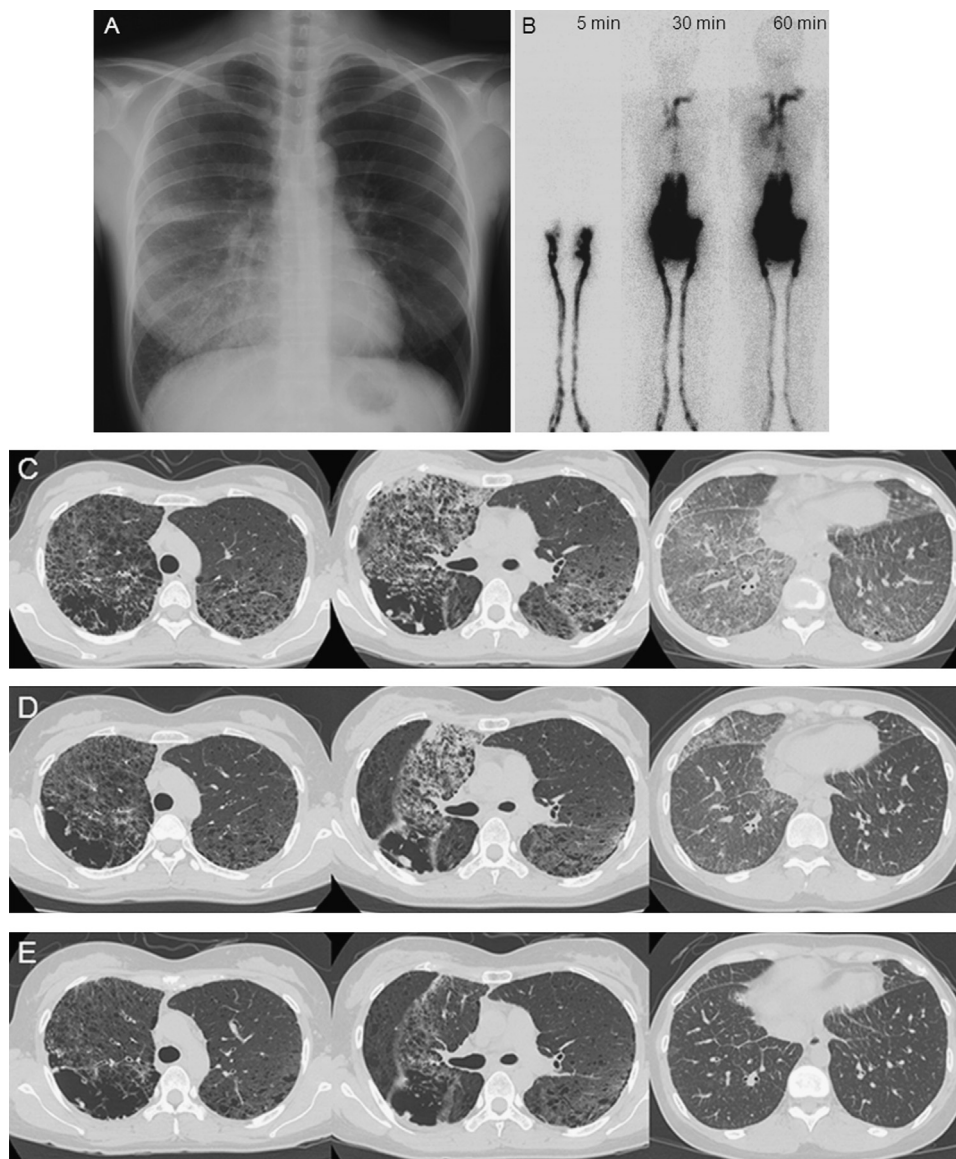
Radiologic findings for patient JUL97, whose pulmonary lymphedema resolved after administration of mTOR inhibitors. This patient's chest radiograph taken at presentation (January 2004) showed ground glass opacity in the right lower lung field (A). Neither pneumothorax nor pleural effusion was found. Lymphoscintigraphy utilizing ^{99m}Tc -labeled human serum albumin (HSA) revealed accumulation of radiolabeled HSA in the right lower lung field, as well as in the retroperitoneal and pelvic lymphangioliomyomas, 60 min after subcutaneous injection of ^{99m}Tc -labeled HAS into the dorsal foot skin, indicating the presence of pulmonary lymphedema (B). Note the double thoracic ducts. Computed tomography (CT) images of the chest showed severe cystic destruction with irregular and bizarre shapes, especially in the right upper, right lower, and left lower lobes, as well as ground glass opacity and thickening of the interlobular septa, indicating pulmonary lymphedema (C, April 2009). Administration of everolimus at 0.5 mg/day began in April 2009, and the dose was increased to 1 mg/day from August 2009 through April 2010. CT images of the chest taken in April 2010 showed lessening of the pulmonary lymphedema (D). The mTOR inhibitor was then changed to sirolimus at 1 mg/day, and CT images of the chest in January 2011 showed almost complete resolution of the pulmonary lymphedema (E).
